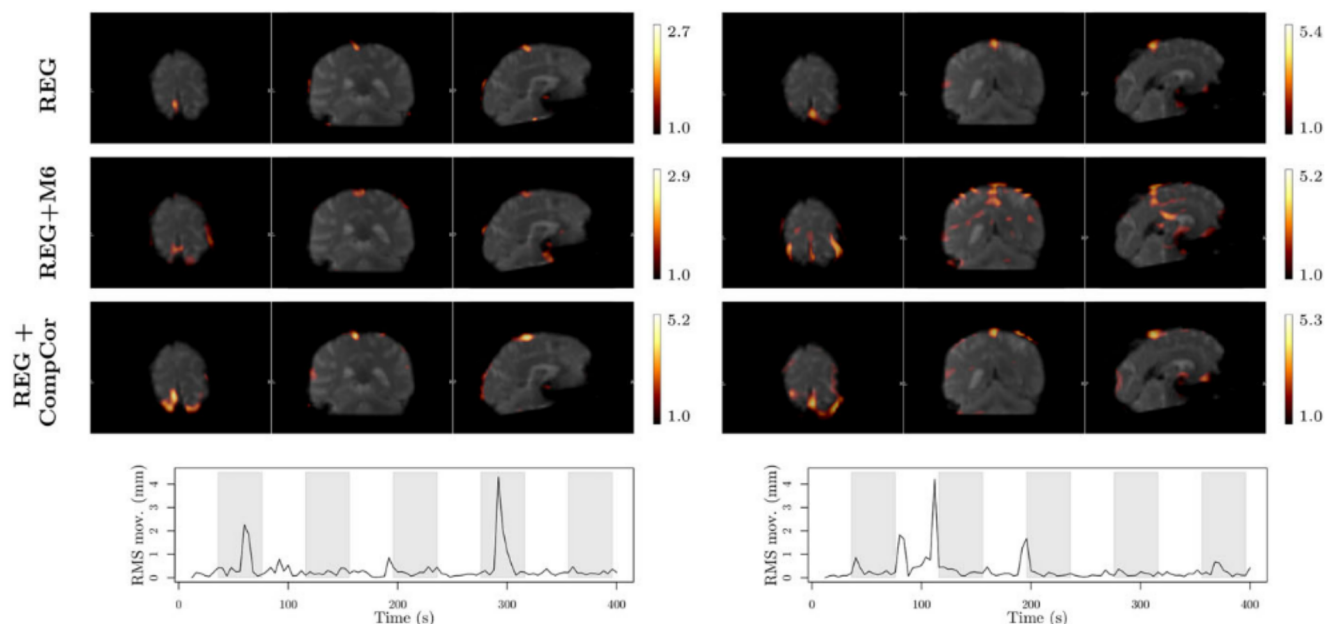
Comparison of the effect of different motion correction techniques at individual-level analysis demonstrated on the activation patterns of a typical patient with high relative (frame-to-frame) root-mean-squared (RMS) in-scanner motion. The orthogonal sections of the activation maps generated by the registration-based uncorrected model (REG) using only realignment of functional MRI images, and the corrected models that include the six motion parameters (REG+M6) or five noise components (REG+CompCor) are shown in the top, middle, and bottom rows, respectively, for the healthy (A) and the paretic leg movement (B). The activation cluster's "cluster occurrence values" ($co = -\log_{10}(p)$) are also indicated. The slices are created in the subject's native space.
